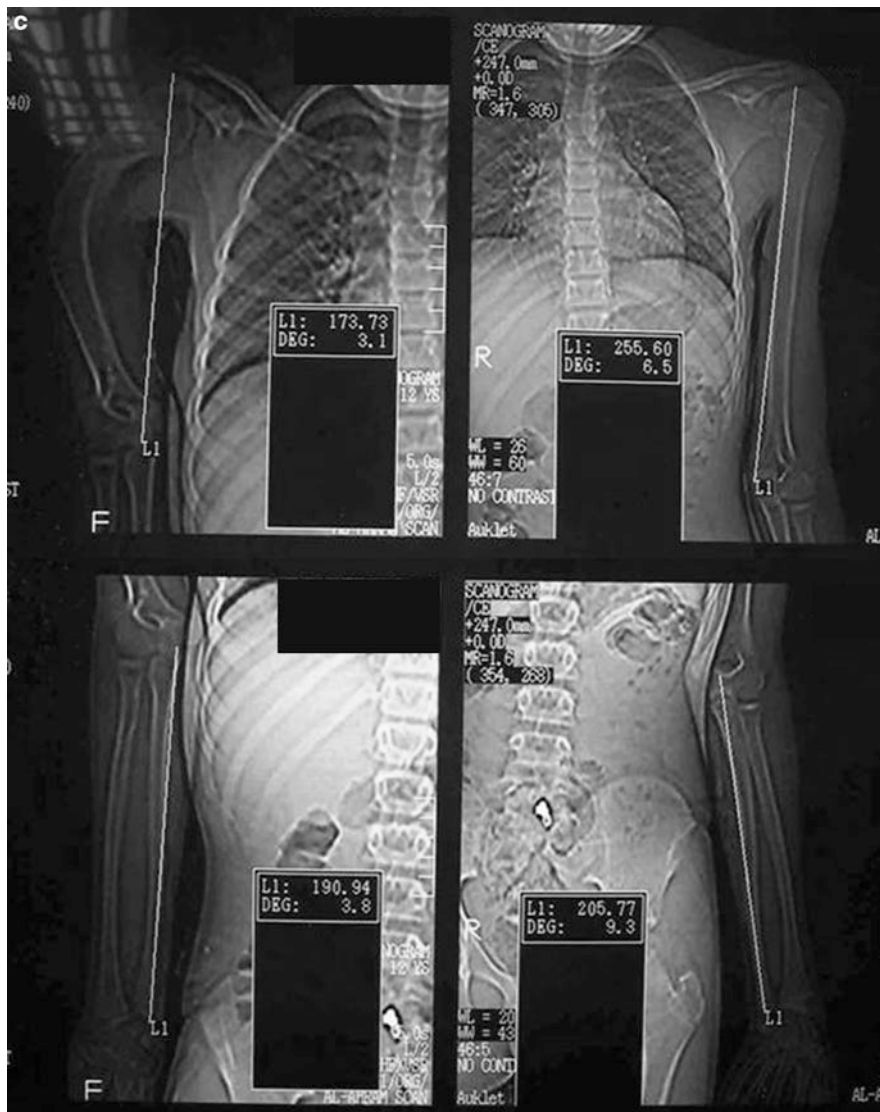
(a) Preoperative photo showing the deformity and shortening of the right humerus. (b) Preoperative radiographs of the right humerus. (c) CT scanogram of both upper limbs
